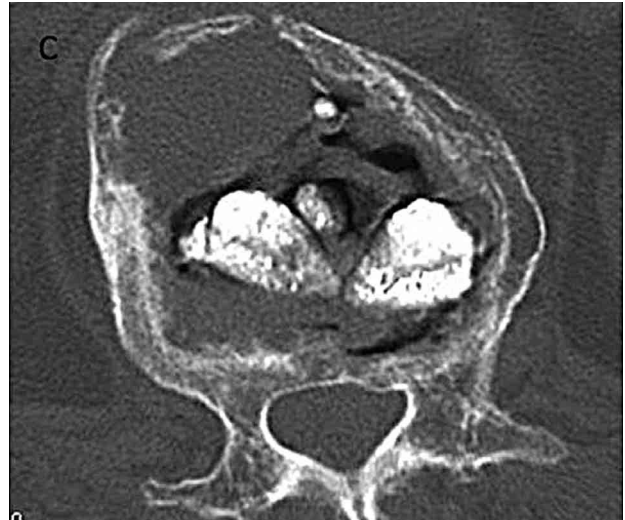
CT scan demonstrating vacuum clefts around the PMMA in the L1 vertebral body.
